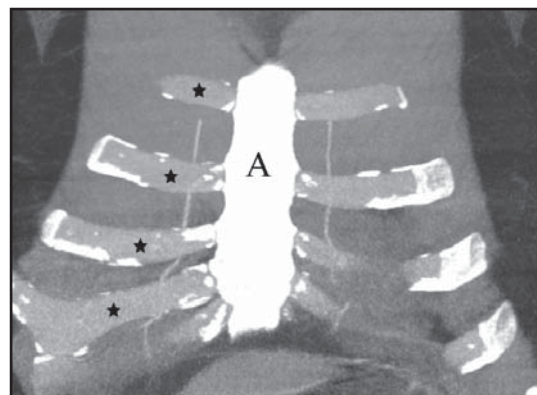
Coronal CT image of the anterior chest. This reformatted image of the anterior chest demonstrates the sternum (A). The stars indicate a few of the anterior ribs, which are composed of costocartilage. The anterior ribs do not appear on chest radiographs unless they are calcified. Note the calcifications that have formed on the proximal and distal segments of the costocartilages in this example.
